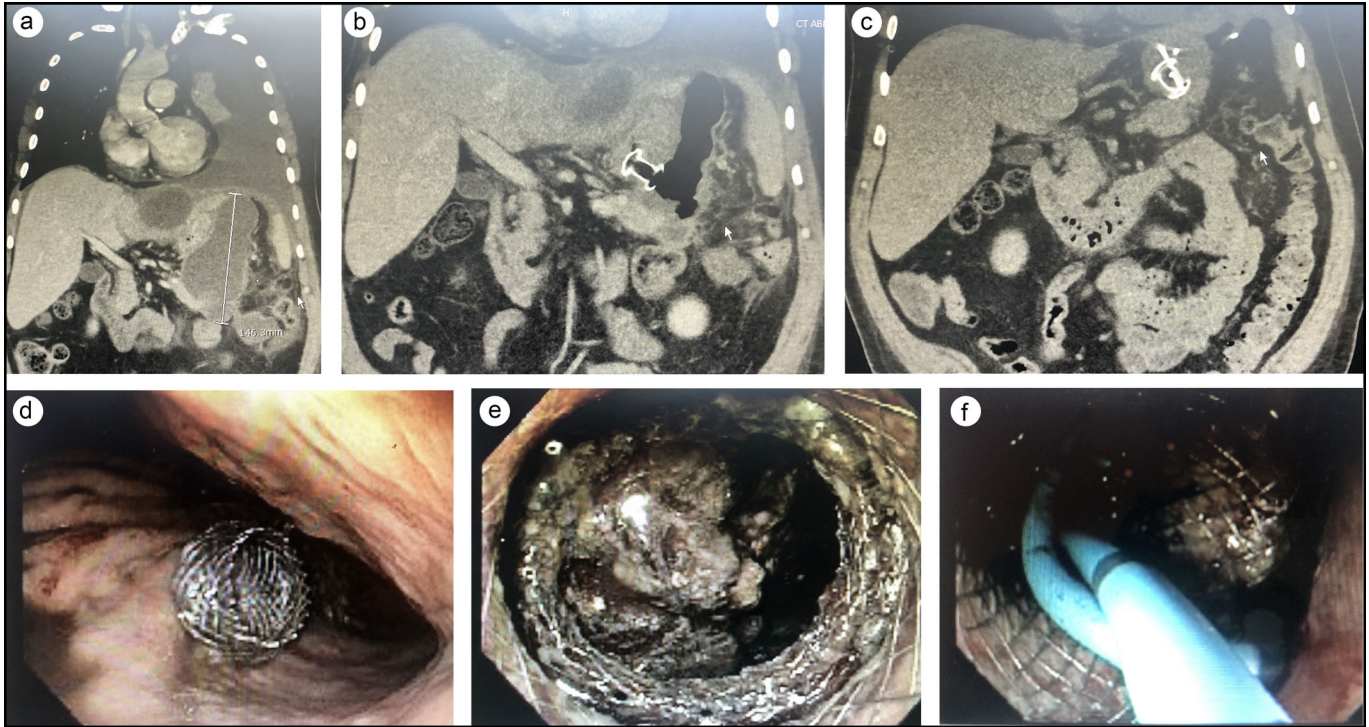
(a) Admission CT scan showing massive left-sided pleural effusion with concurrent pancreatic and hepatic subcapsular fluid collections. (b) Scan after endoscopic ultrasound-guided cyst gastrostomy with a cautery-enhanced, lumen-apposing metal stent, followed by endoscopic pancreatic necrosectomy, debridement, and placement of two transgastric pigtail stents into the walled-off pancreatic necrosis cavity. (c) Three-month follow-up showing complete resolution of the pancreatic and pleural fluid collections. (d) A transgastric lumen-apposing metal stent in the stomach. (e) Necrotic tissue within the cavity, seen via the lumen-apposing metal stent. (f) Placement of two double pigtail stents into the walled-off necrosis cavity to facilitate entry of gastric acid/sanitation of contents.
